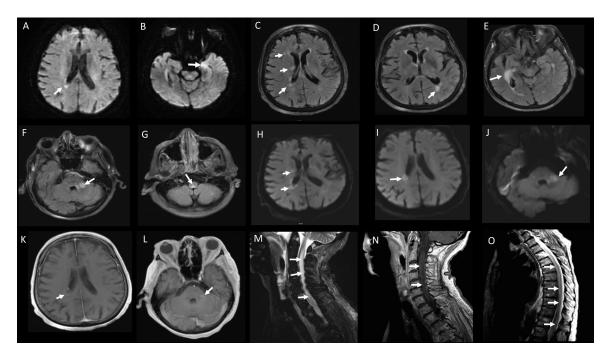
MRI Brain Sequences; A & B: DWI; [A] Right periventricular restricted diffusion and [B]Left mesial temporal lobe restricted diffusion. C-G: T2 Flair; [C], multiple foci of high signal right periventricular, [D] high signal left temporal horn periventricularly, and [E] high signal right temporal horn perimetrically, [F] high signal left middle cerebellar peduncle, [G] high signal around the 4th ventricle. H, I & J: DWI; [H]and [I]; Restricted diffusion periventricularly and [J] restricted diffusion left MCP. K & L: T1– Post contrast, [K] Incomplete ring of enhancement right periventricular and left MCP [L]. M: MRI Cervical Cord T2: Increased signal throughout cervical spinal cord, N: MRI Cervical cord T1-Post contrast: Faint contrast enhancement in the ventral cervical cord, O: MRI Thoracic Spine T2: High signal throughout the thoracic cord.
